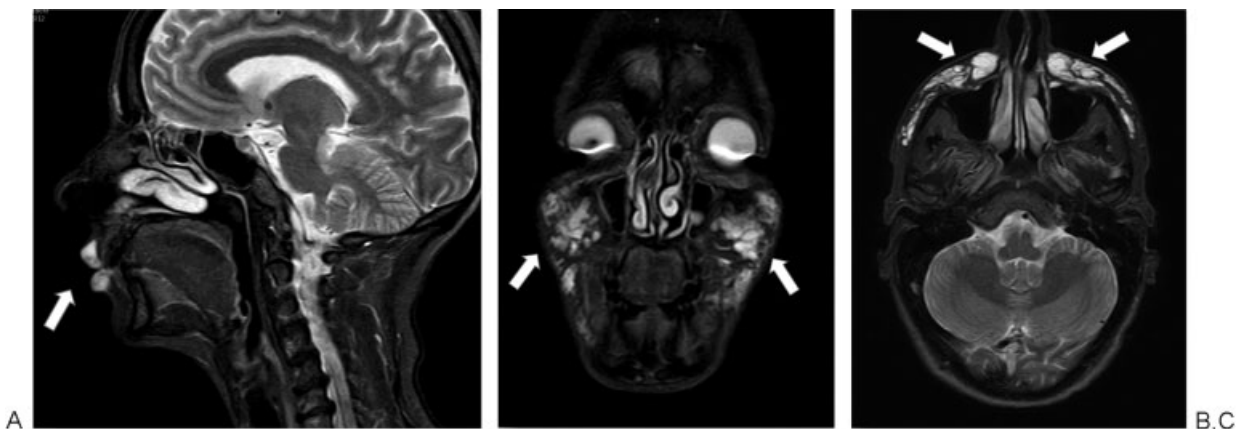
Assessment of the distribution of hyaluronic acid after lip (A) and cheek augmentation (B, C) using magnetic resonance imaging with fat-suppression technique.
